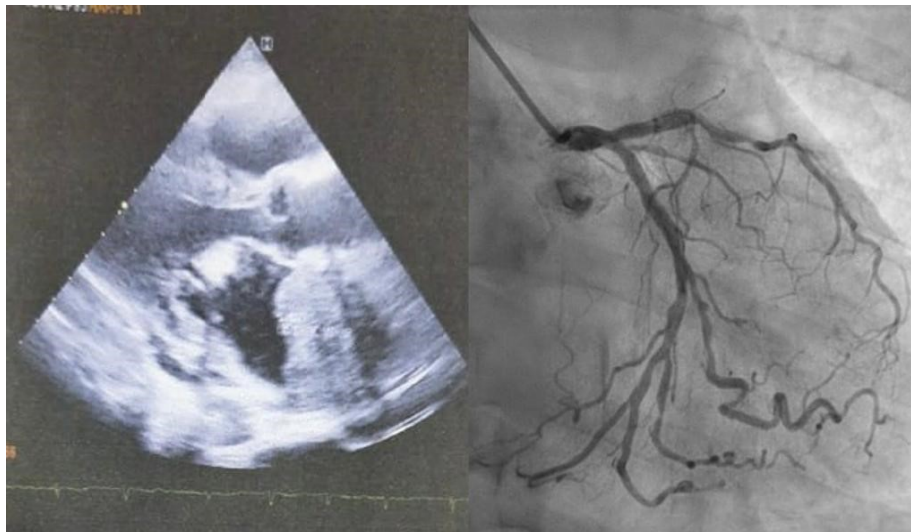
LA thrombus was revealed by echocardiography and coronary angiography showed multiple stenosis.
